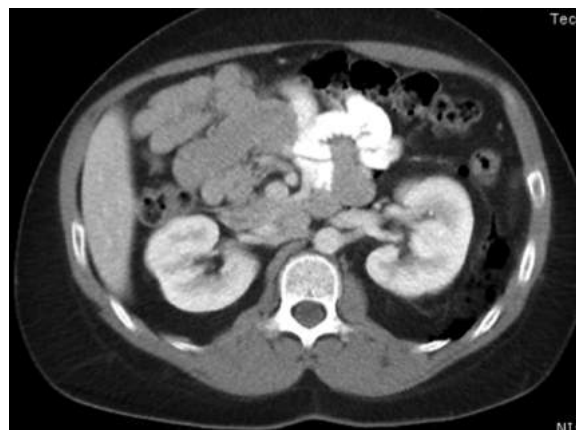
CT scan of the abdomen/pelvis with intravenous contrast demonstrating retroperitoneal free air and diverticulosis of the transverse colon.
